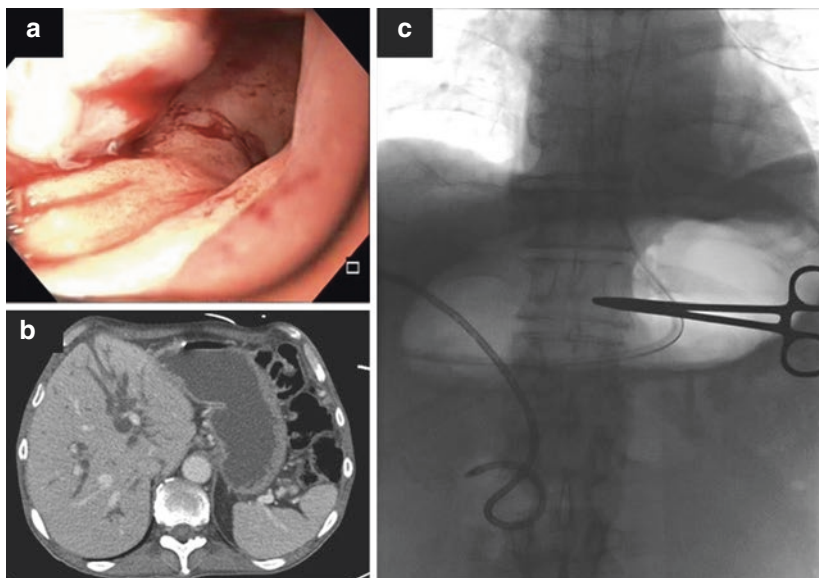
(a) Endoscopic image of a metastatic ovarian lesion resulting in complete duodenal obstruction in a patient requiring decompressive PEG. (b) Involvement of gastric wall and the altered anatomy due to tumor burden seen on CT complicate traditional PEG placement methods. (c) Fluoroscopy was utilized for optimal placement. Surgical instrument placed on the abdomen was used to mark ideal decompressive PEG placement location. Percutaneous transhepatic biliary drain is seen in situ
